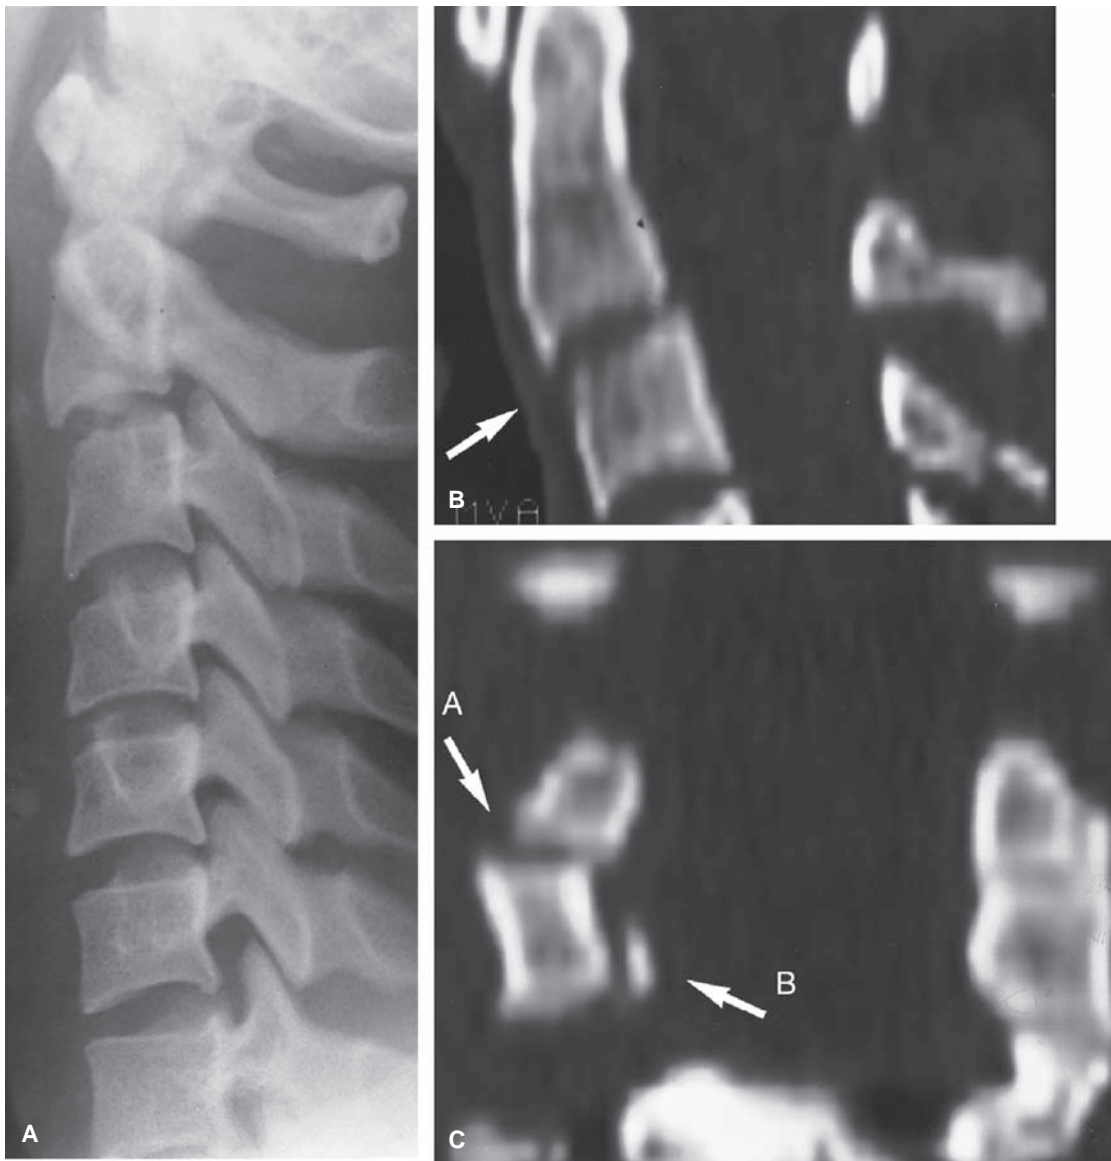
A: Apparently “normal” lateral cervical spine radiograph (16-year-old patient after motor vehicle accident). B: Spiral computed tomography (CT) scan demonstrating dens fracture (*arrow*). C: Sagittal view of spiral CT scan demonstrating dens fracture (*arrow A*) and vertebral body avulsion fracture (*arrow B*). The detail demonstrated by the spiral CT scan could help clinicians quickly identify lesions not easily visible or appreciated on conventional radiographs.
